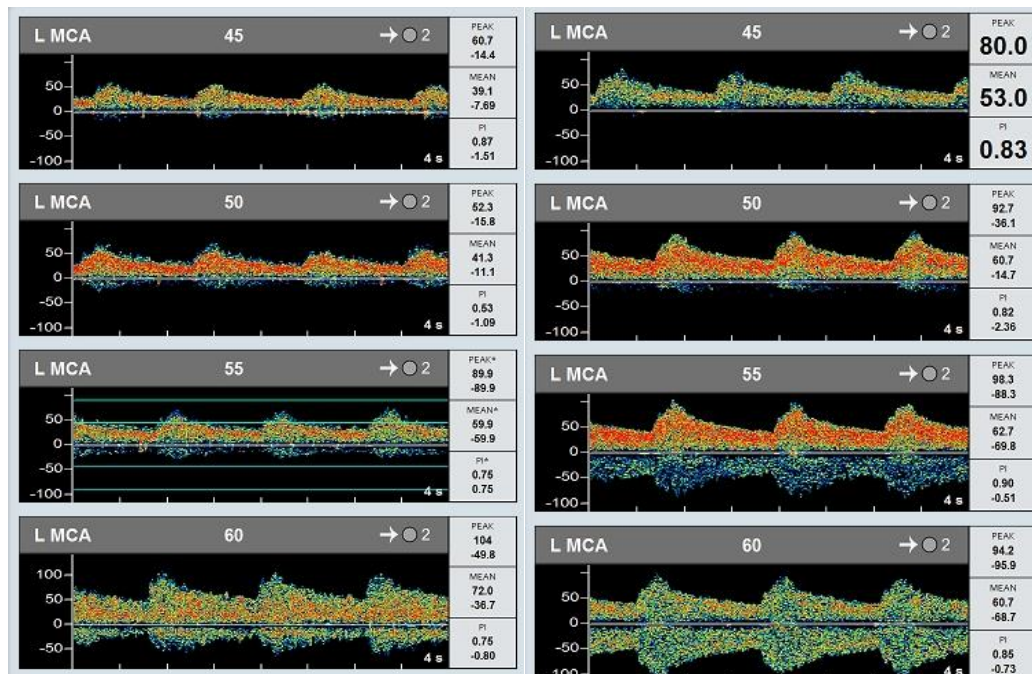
Left: Transcranial doppler sonography (TCD) done 1-day post-ictus showing with dampened waveforms and decreased mean flow velocities in the middle to distal segments of the left middle cerebral artery (45-55mm depth). Right: TCD done 4 days post-ictus revealing improvement of the mean flow velocities of the middle to distal segments of the left middle cerebral artery.
